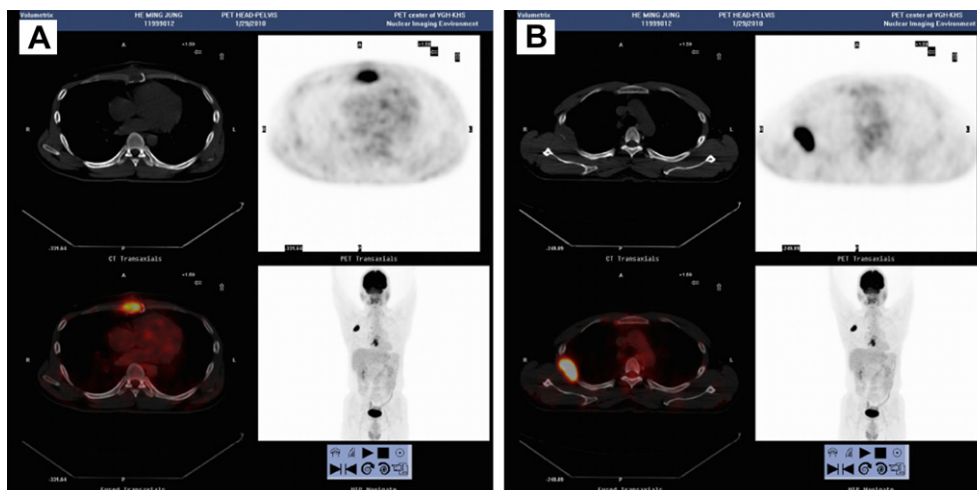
Images of case 2. Positron emission tomography-computed tomography scan demonstrating fluorodeoxyglucose-avid lesions in (A) the sternal body [Maximal Standard Uptake Value, 7.4] and (B) the lateral right 4th rib [Maximal Standard Uptake Value, 15.2].
